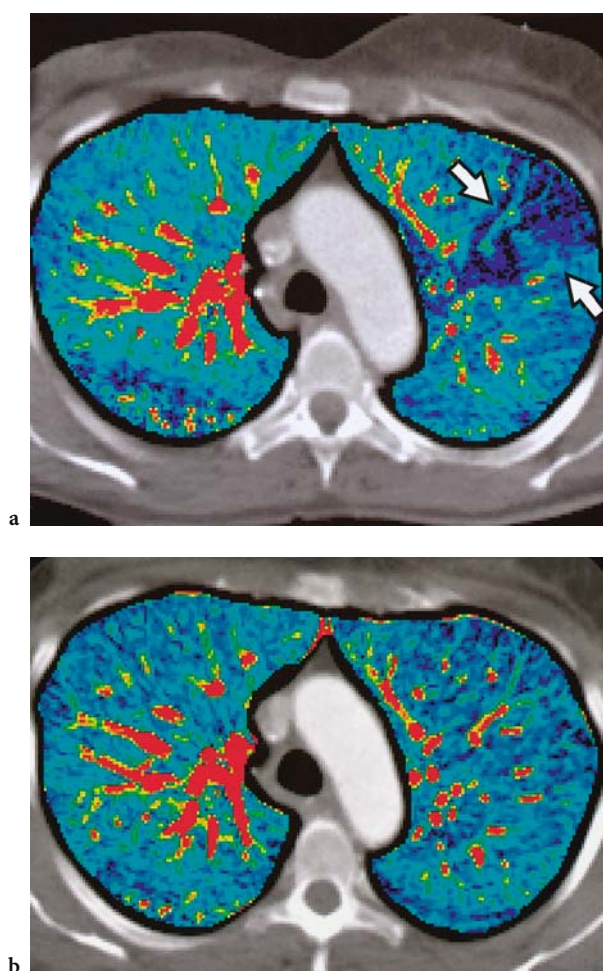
Color coded perfusion map obtained with dynamic electron beam CT. A Perfusion defect due to pulmonary embolism (arrows) in left upper lobe. B Follow-up after heparin therapy (SCHOEPF et al. 2000, with permission)
